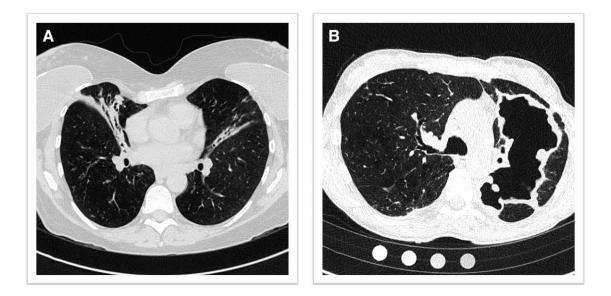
Axial chest computed tomography scans of 2 patients with *Mycobacterium avium* complex pulmonary diseases. *A*, A woman with a tall-slender build, pectus excavatum, and nodular bronchiectatic disease in the right middle lobe and lingula. *B*, A patient with fibrocavitary disease.
